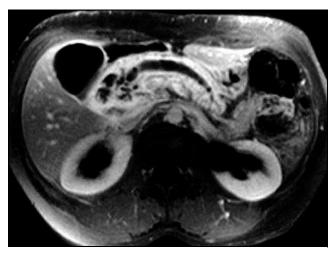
MRI of a patient with IPMT of the pancreatic head. Note characteristic dilation of the main duct and side branches.
